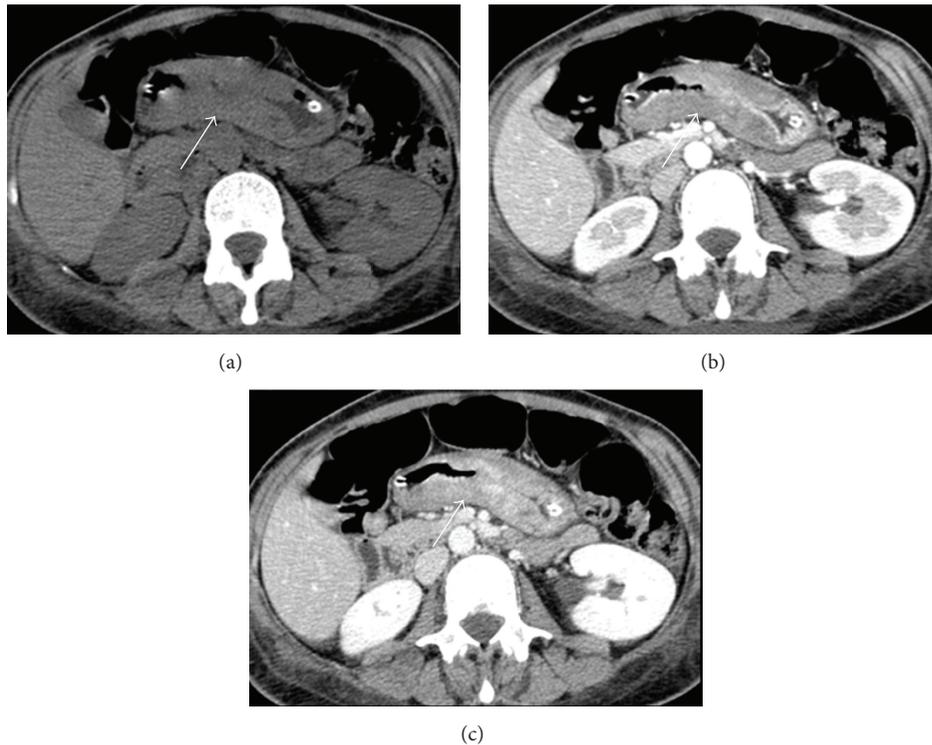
Abdominal CT scan in a 48-year-old female with gastric lymphoma. Axial pre- (a) and postcontrastographic CT scan in the arterial (b) and portal venous (c) phase show diffuse segmental (length: 9 cm) wall thickening (thickness: 1,8 cm) (arrows) of the gastric corpus and antrum with mild contrast enhancement. The patient underwent gastrectomy with ileal-jejunum anastomosis.
